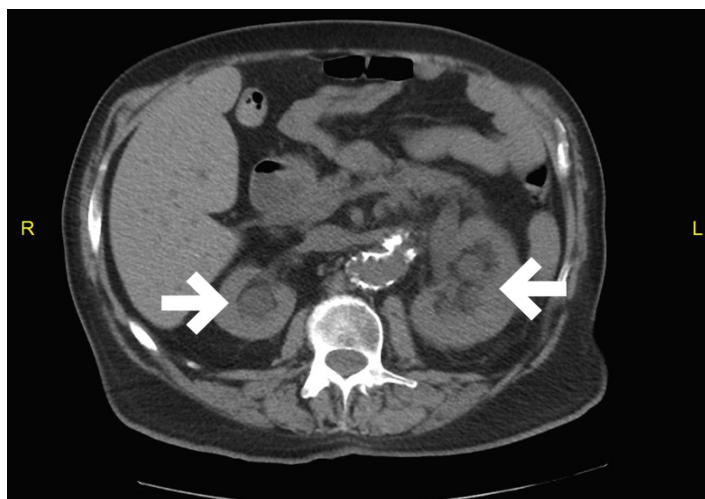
Computed tomography of the abdomen and pelvis in axial view with arrows demonstrating bilateral hydronephrosis
